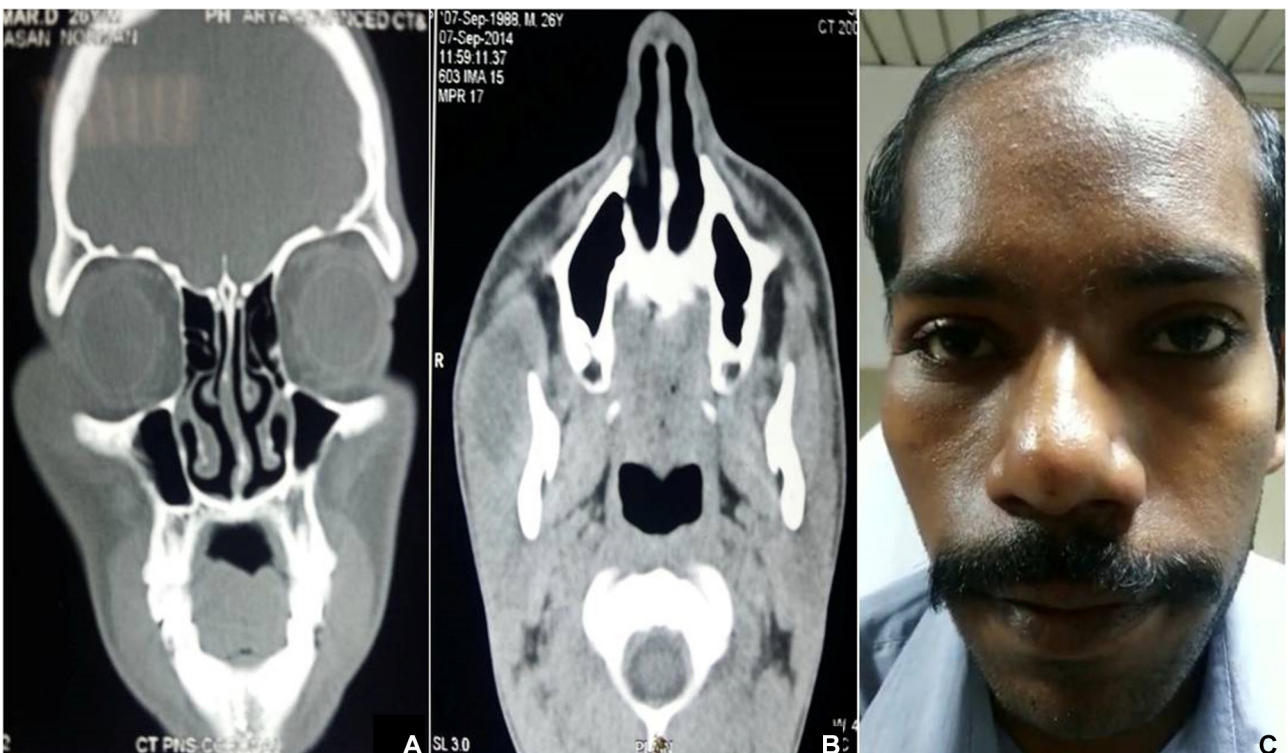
(A, B) Contrast-enhanced MRI showing bilobed cystic lesion in the right masseter muscle with extension up to zygomatic arch. (C) Regression of the swelling following antitubercular treatment.
